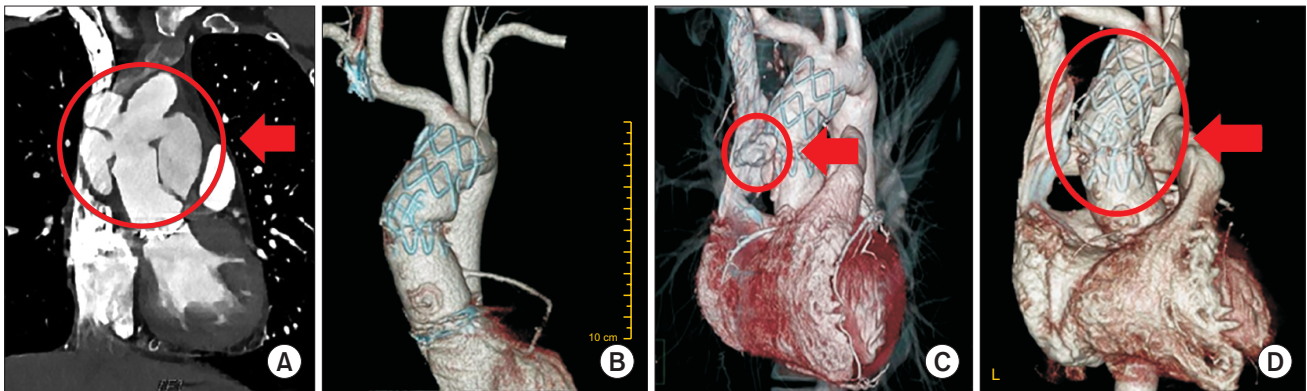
(A) CT showed multiple outpouching aneurysms (arrow) in the ascending aorta. (B) Three months after the TEVAR procedure. Reconstructed 3D-CT showed a smaller pseudoaneurysm sac than on the previous CT scan. (C) Seven months after the TEVAR procedure. Reconstructed 3D-CT showed type IV endoleak at the site of TEVAR (arrow). (D) Reconstructed 3D-CT showed no sign of endoleak at the previous endoleak site (arrow). CT, computed tomography; TEVAR, thoracic endovascular aortic repair; 3D, 3-dimensional.
